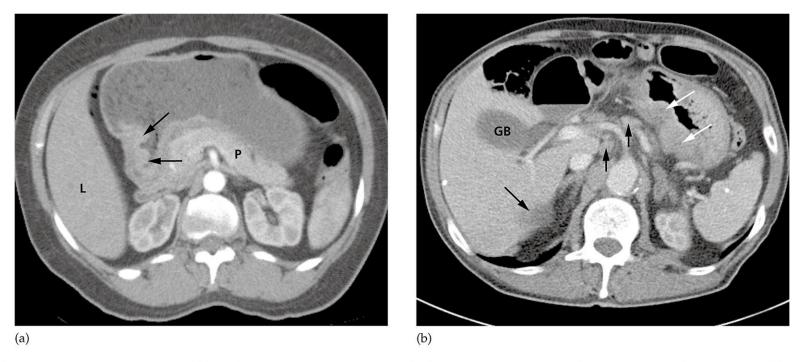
Gastric carcinoma on CT. (a) A focal ulcer is seen arising in the antrum (arrows). (b) In a different patient, there is diffuse thickening of the wall of the stomach (white arrows). Several lymph nodes (short black arrows) and a liver metastasis (long black arrow) are also seen. GB, gall bladder; L, liver; P, pancreas.
